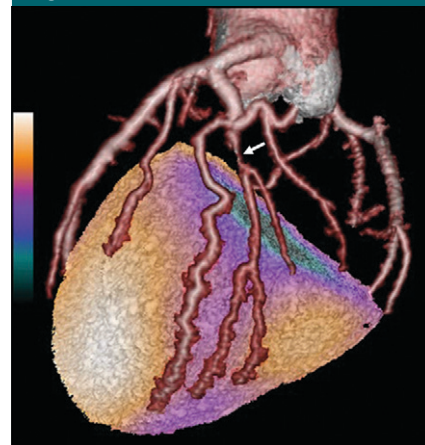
Three-dimensional volume-rendered cardiac PET/CT image from fused rubidium 82 vasodilator stress PET with coronary CT angiography. Coronary CT angiographic component demonstrates high-grade stenosis (arrow) in the second obtuse marginal branch. PET component shows medium-sized, moderate perfusion defect (purple hue) in the corresponding lateral myocardium.
